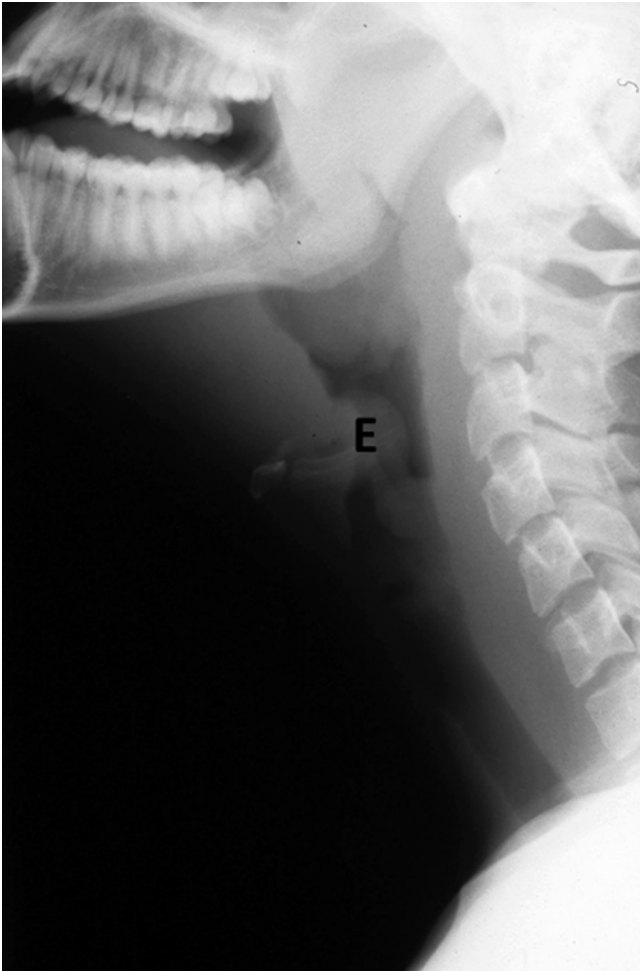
Epiglottitis in a 6-year-old girl with fever, sore throat and drooling. Lateral radiograph shows enlarged epiglottis (*E*), which narrows upper airway (Reprinted with permission from American Journal of Roentgenology, page W168, 2013)
